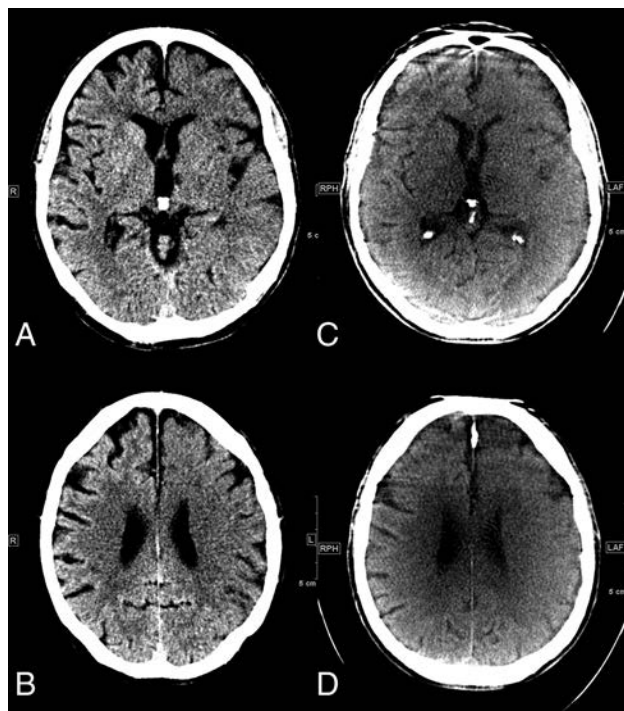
A, Initial MDCT in the peripheral stroke center shows hypodensities of the left striatum, insula, internal capsule, M1, M2, and M3 segments. B, In the supraganglionic levels, we observe early signs in the M4, M5, and M6 segments, resulting in an ASPECTS of 0. C and D, FDCT acquired in our comprehensive stroke center 94 minutes after the initial CT shows early ischemic signs in the left anterior cerebral artery and MCA territories, resulting in an ASPECTS of 2. The M3 and M6 segments are not classified as ischemic on FDCT images.
